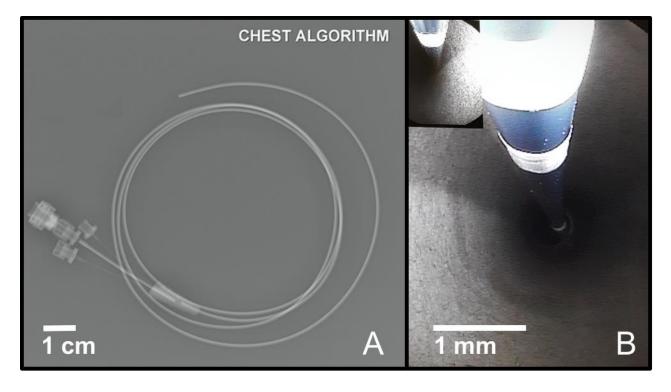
(A) TLBC catheter under x-ray imaging in a chest algorithm. (B) The white depth marking bands are clearly visible using the integrated camera on the flexible bronchoscope.
